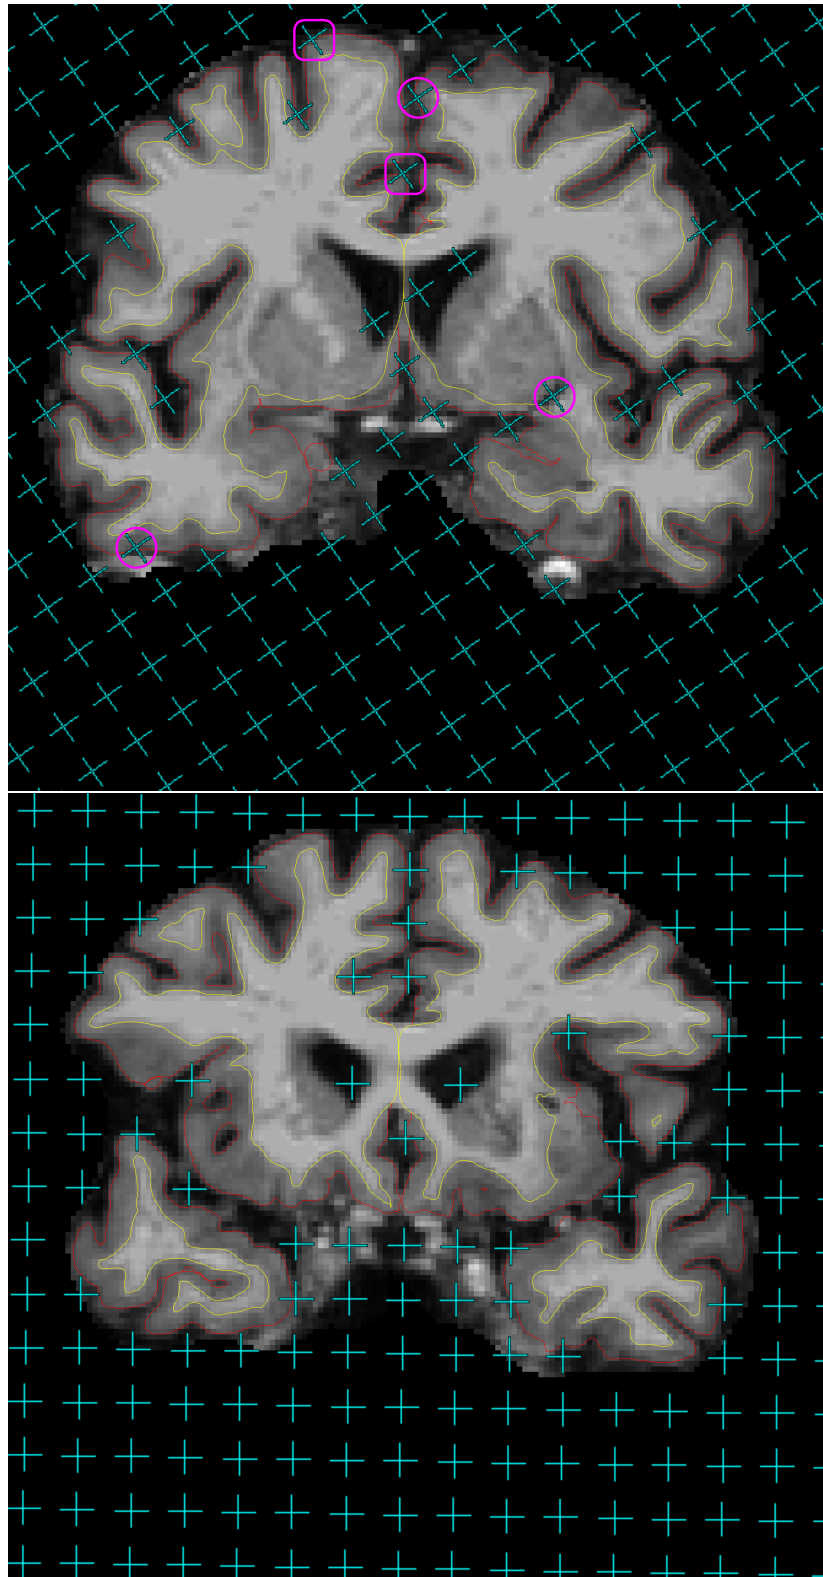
On the 11th and 12th slices of one brain MR image in the coronal view, uncounted test points (cyan) which miss the cerebral parenchyma or hit the ventricles are overlaid onto pial profiles (red lines) segmented by FREESURFER. Circles (pink) mark the uncounted test points which fall inside the grey matter boundaries (red lines) and rounded rectangles (pink, racetrack-like) mark the test points hitting exactly on the grey matter boundaries.
